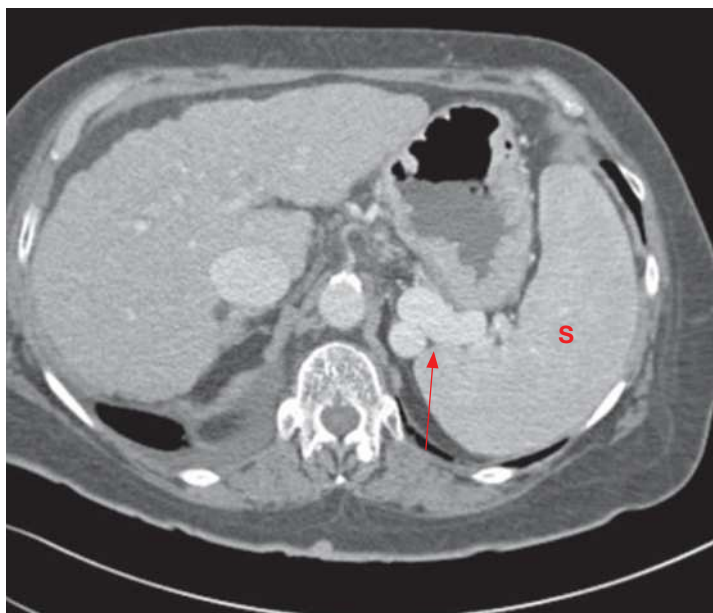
Cirrhosis. Transaxial image from contrast-enhanced CT shows a nodular liver contour and the stigmata of portal hypertension, including splenomegaly (S) and perisplenic varices (*arrow*). (Reproduced with permission from USMLE-Rx.com.)
